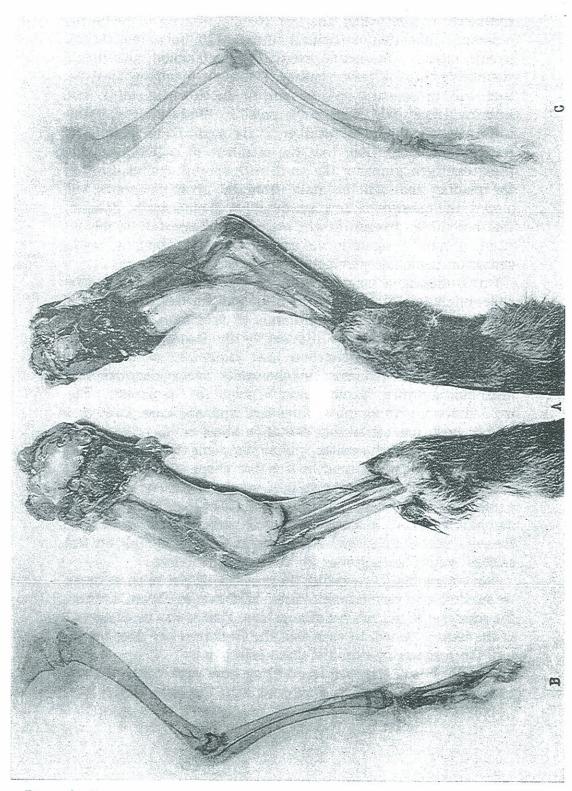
VERY EXTENSIVE PURULENT ARTHRITIS, WHICH HAS EXTENDED BEYOND THE JOINT CAPSULES AND BETWEEN THE MUSCLES. NOTE: THE ROENTGENOGRAM FAILS TO DISCLOSE THE INFECTION.
